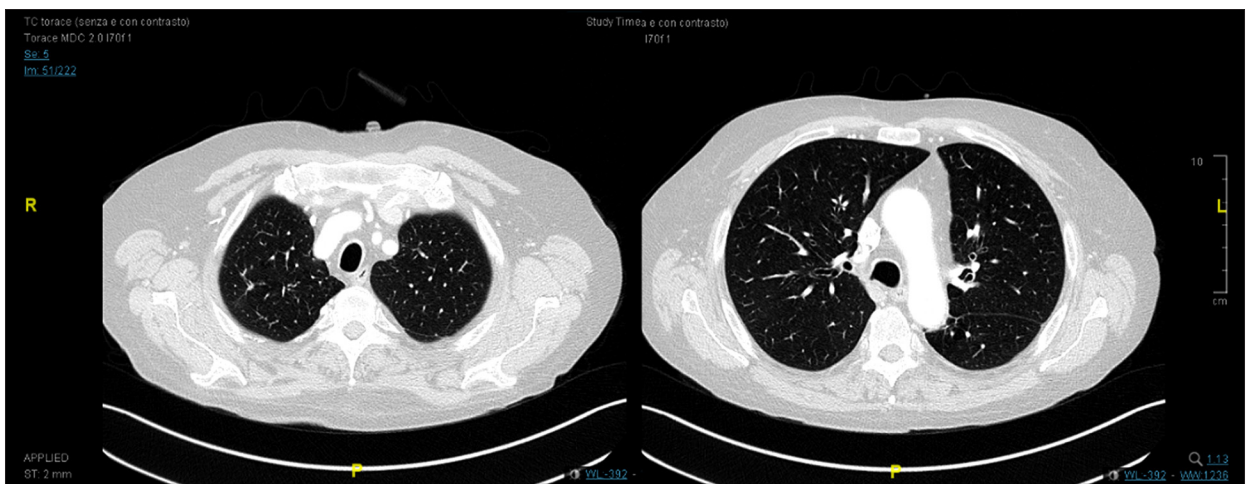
Improvement after 6 months of therapy. Axial contrast-enhanced thorax computed tomography scan (2 sections) showing fairly complete resolution of bilateral “ground-glass” areas, persistence of few small foci in the middle lobe. Minimum left-sided pleural effusion.
